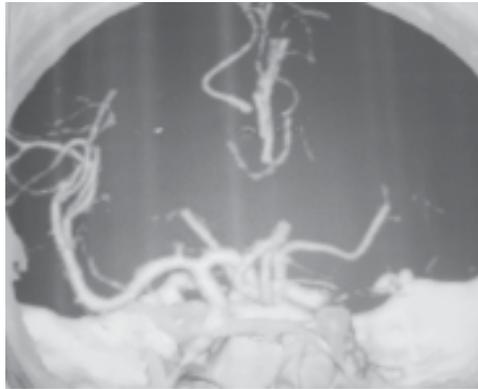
CT Angiogram shows the total occlusion of left ICA and stenosis and partial visualisation of left MCA by contralateral flow.
